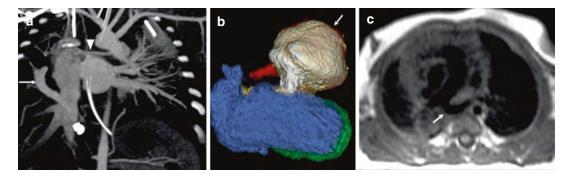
Congenital cardiovascular anomalies. (a) Coronal CT angiogram in a patient with scimitar syndrome. Anomalous pulmonary vein draining into the infradiaphragmatic IVC (arrow) and hypoplastic right pulmonary artery (arrowhead). (b) Three-dimensional CT angiogram reformat in patient with history of tetralogy of Fallot status post repair shows a large postsurgical ventricular conduit aneurysm (arrow). (c) T1 axial MRI image in neonate with pulmonary sling shows an aberrant left pulmonary artery (arrow) arising from the right and encircling the trachea and esophagus
